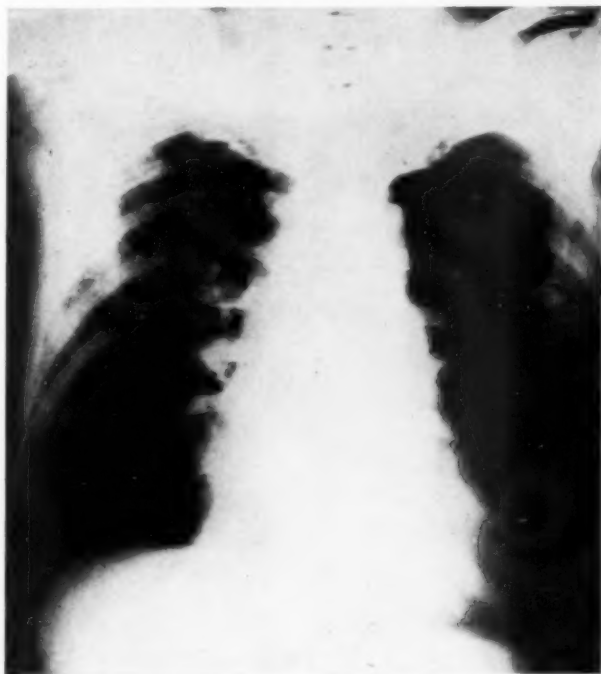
Roentgenogram taken October 11, 1941, showing cardiac enlargement and passive congestion through the lungs.
